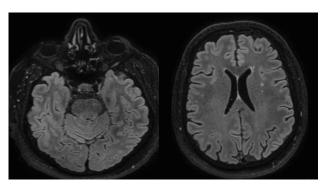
Few tiny T2/FLAIR hyperintense foci are seen in the left frontal white matter, likely minor chronic microangiopathic changes.
